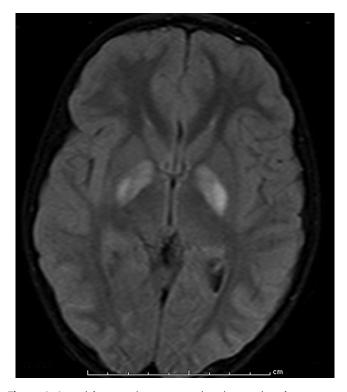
An axial magnetic resonance imaging section demonstrates lesions of the globus pallidus bilaterally. The lesions are hyperintense on T_2 -weighted and fluid attenuated inversion recovery sequences.
